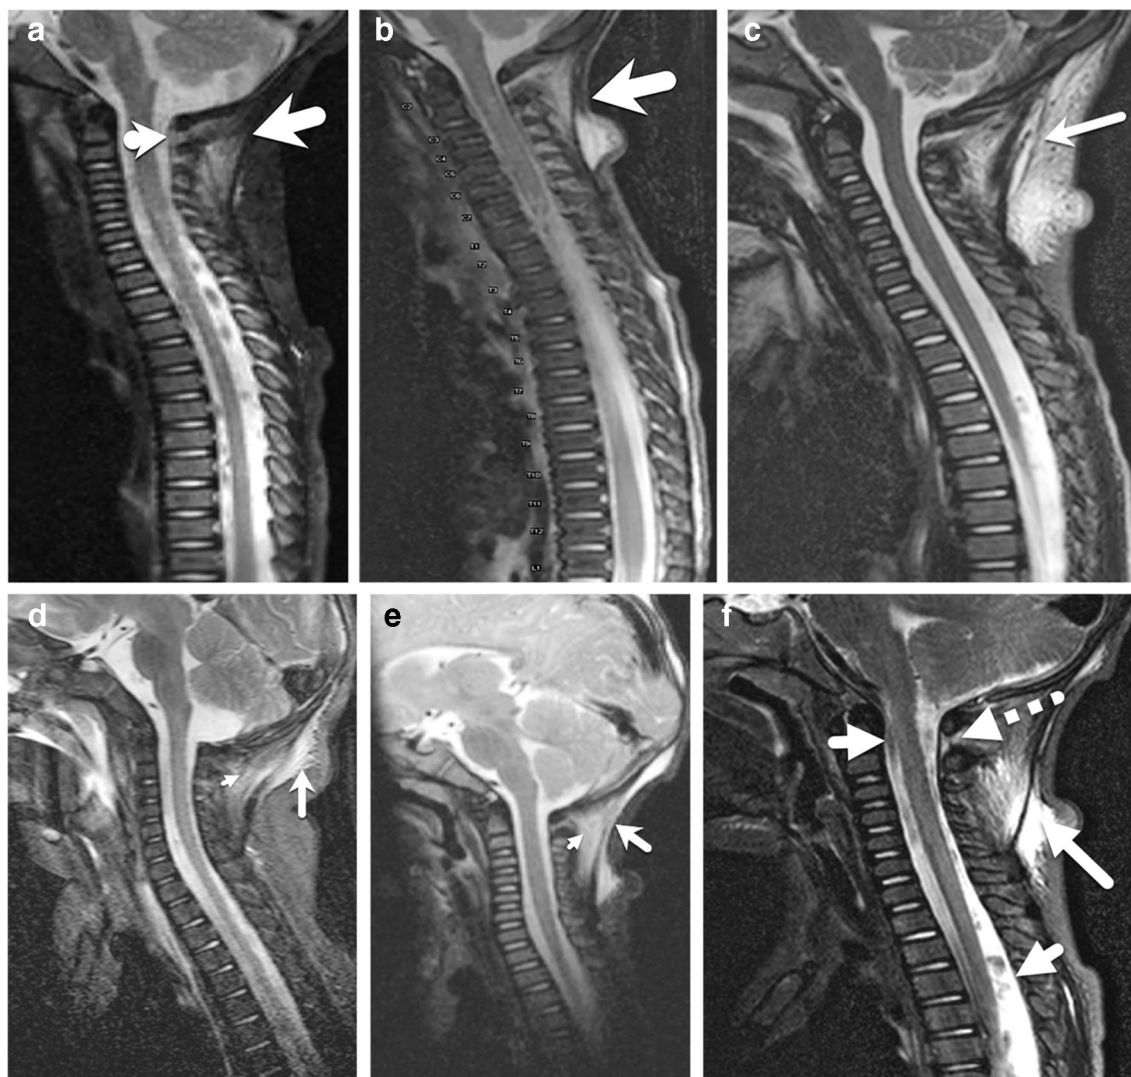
Various patterns of nuchal ligament injury on short tau inversion recovery (STIR) MRI in multiple children with abusive head trauma. a Sagittal STIR image of the cervical spine in a 6-month-old boy demonstrates T2 hyperintensity of the nuchal ligament (*large arrow*) as well as along the atlanto-occipital and atlanto-axial membrane (*small arrow*). Note the absence of significant subcutaneous edema. b Sagittal STIR image of the cervical spine in a 2-month-old girl demonstrates T2 hyperintensity of the nuchal ligament (*arrow*) as well as along the atlanto-occipital and atlanto-axial membrane. There is also evidence of injury to the interspinous ligaments. Edema is evident, particularly along the thoracic spine region. c Sagittal STIR of the cervical spine in a different 2-year-old girl demonstrates extensive injury of the suboccipital soft-tissue structures. There is a collection along the nuchal ligament (*arrow*). Note the edema along the lamellar membrane extending deep to the atlanto-axial membrane. There is also extensive subcutaneous edema. d Sagittal STIR of the cervical spine in an 11-month-old boy demonstrates evidence of injury to the nuchal ligament along its upper
